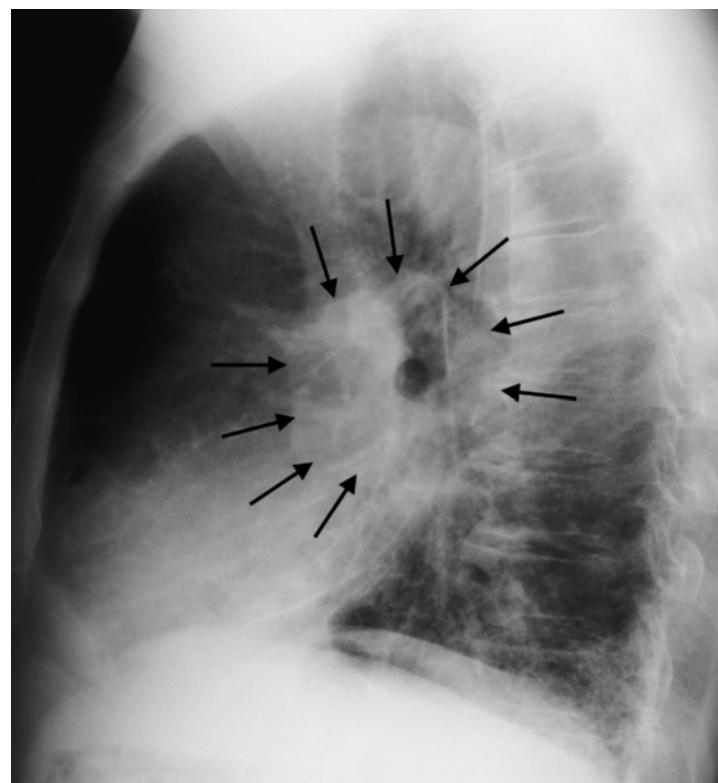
Significant thickening of all hilar structures in pulmonary arterial hypertension. Findings on a preoperative chest radiograph of a 79-year-old male smoker. There is diffuse peribronchial shadowing in a finely nodular pattern. Areas of basal fibrosis are beginning to show honeycombing. There is global heart enlargement without signs of decompensation. The entire hilum is homogeneously thickened (black arrows). Caution: The thickened structures are always densest at the center.
